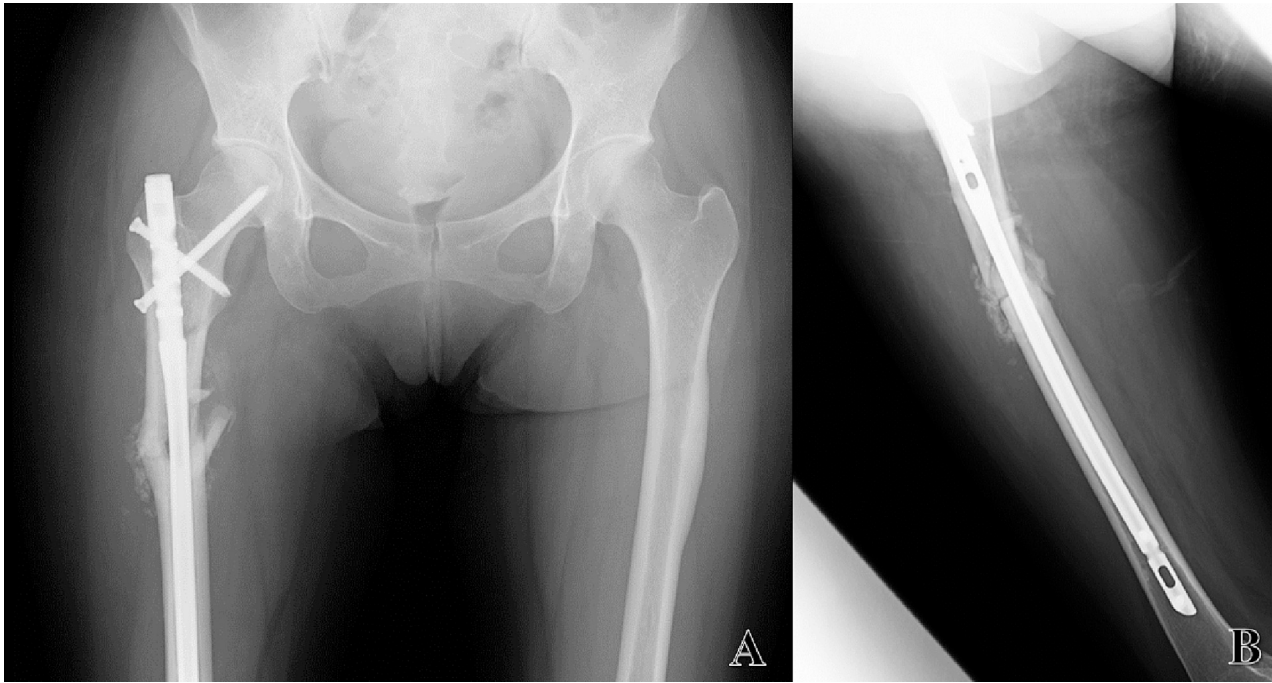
(A) Anteroposterior (AP) and (B) lateral radiographs taken 5 after surgery show a callus formation focusing on bone graft.
